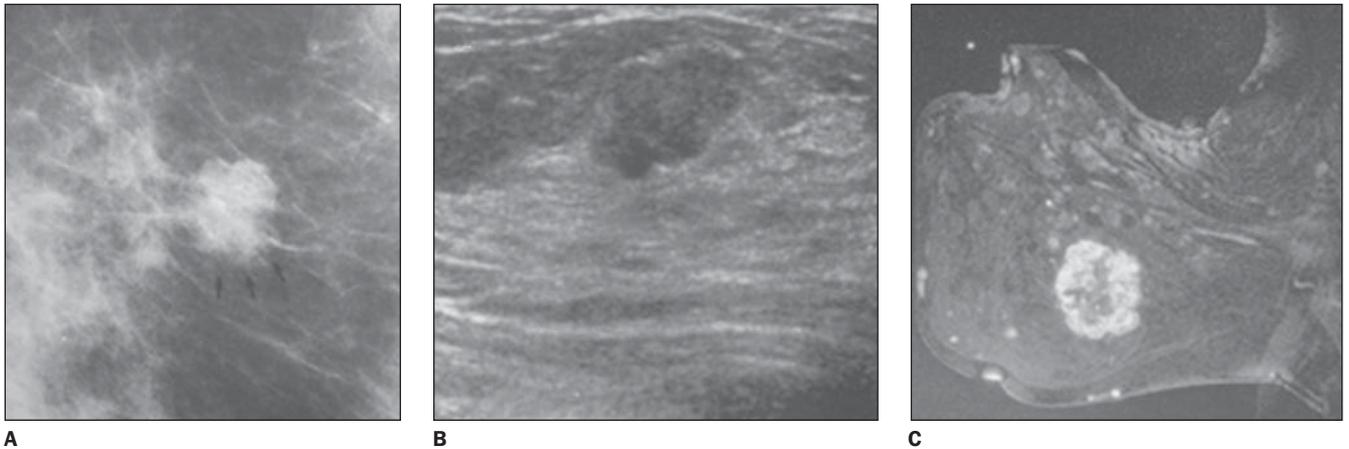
Examples of nodules classified as BI-RADS category 4. A: Mammographic image showing an isodense, irregular nodule with microlobulated margins. B: Sonographic image showing hypoechoic, ovoid nodule with microlobulated margins and presenting non-parallel orientation. C: Contrast enhanced magnetic resonance image showing circumscribed, lobulated nodule, with a ring-like enhancement.
